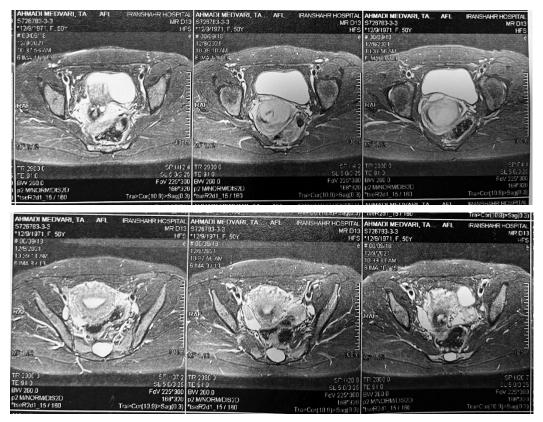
Pelvic MRI showed an enlarged uterus
